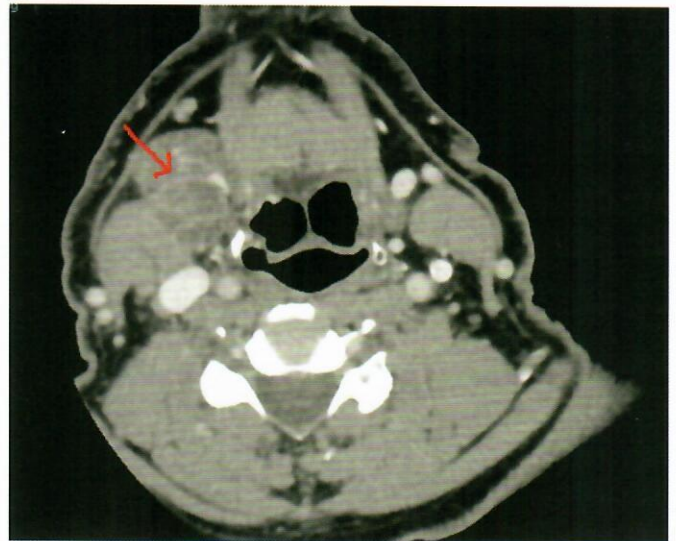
CT scan demonstrating enlarged cervical lymph nodes.
